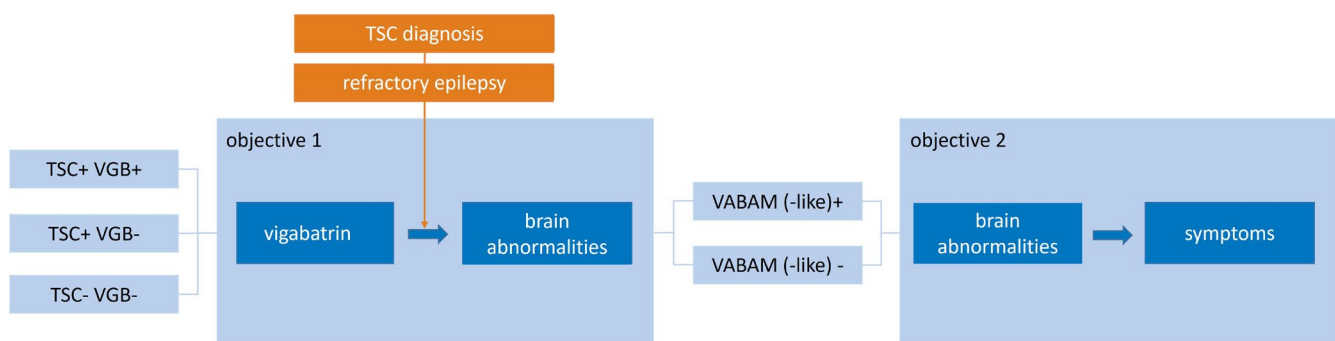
Study objectives. TSC, tuberous sclerosis complex; VABAM, VGB-associated brain abnormalities on magnetic resonance imaging; VABAM (-like), VABAM or VABAM-like changes; VGB, vigabatrín.
